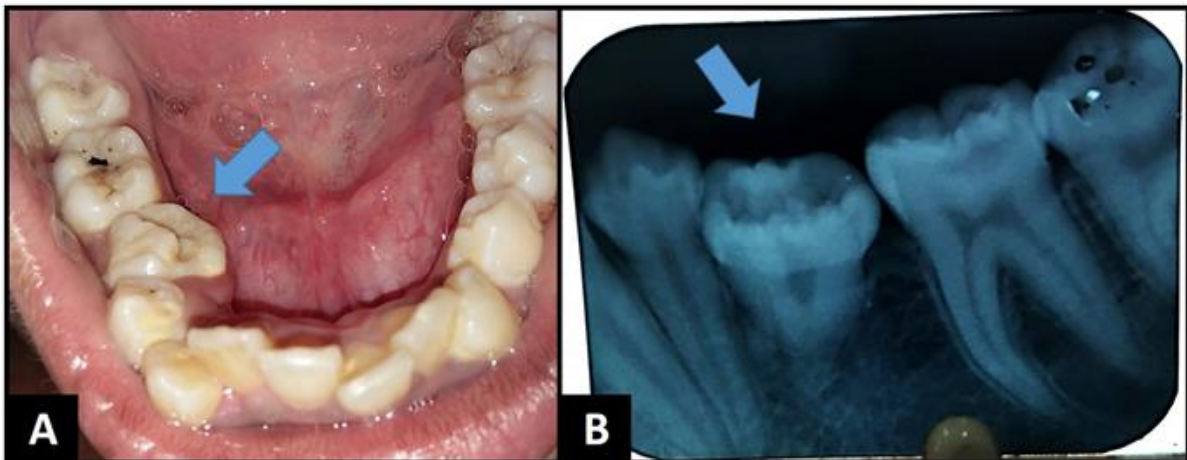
Premolar Molarization: A – Clinical View. B – Radiographic View.
